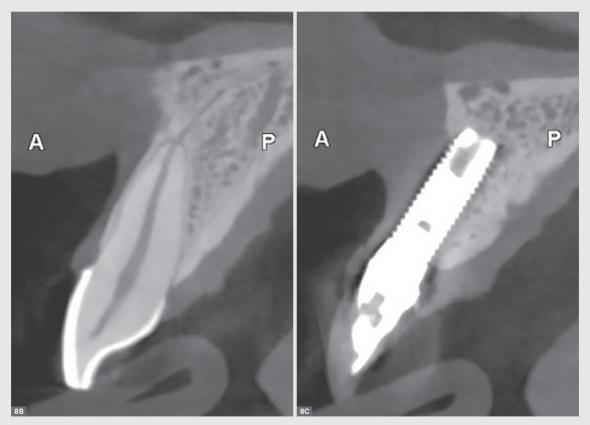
and 8C: B) Cone Beam Computed Tomography (CBCT) – transaxial reconstruction of the region of tooth #11: it is possible to observe the position of anatomic structures such as the cemento–enamel junction, gingival margin and bone crest. C) CBCT – transaxial reconstruction of the region of tooth #21: presence of an implant, there was no oral bone wall, the soft tissues showed low thickness and there was a difference in angulation between the prosthetic component and the insertion axis of the implant.
